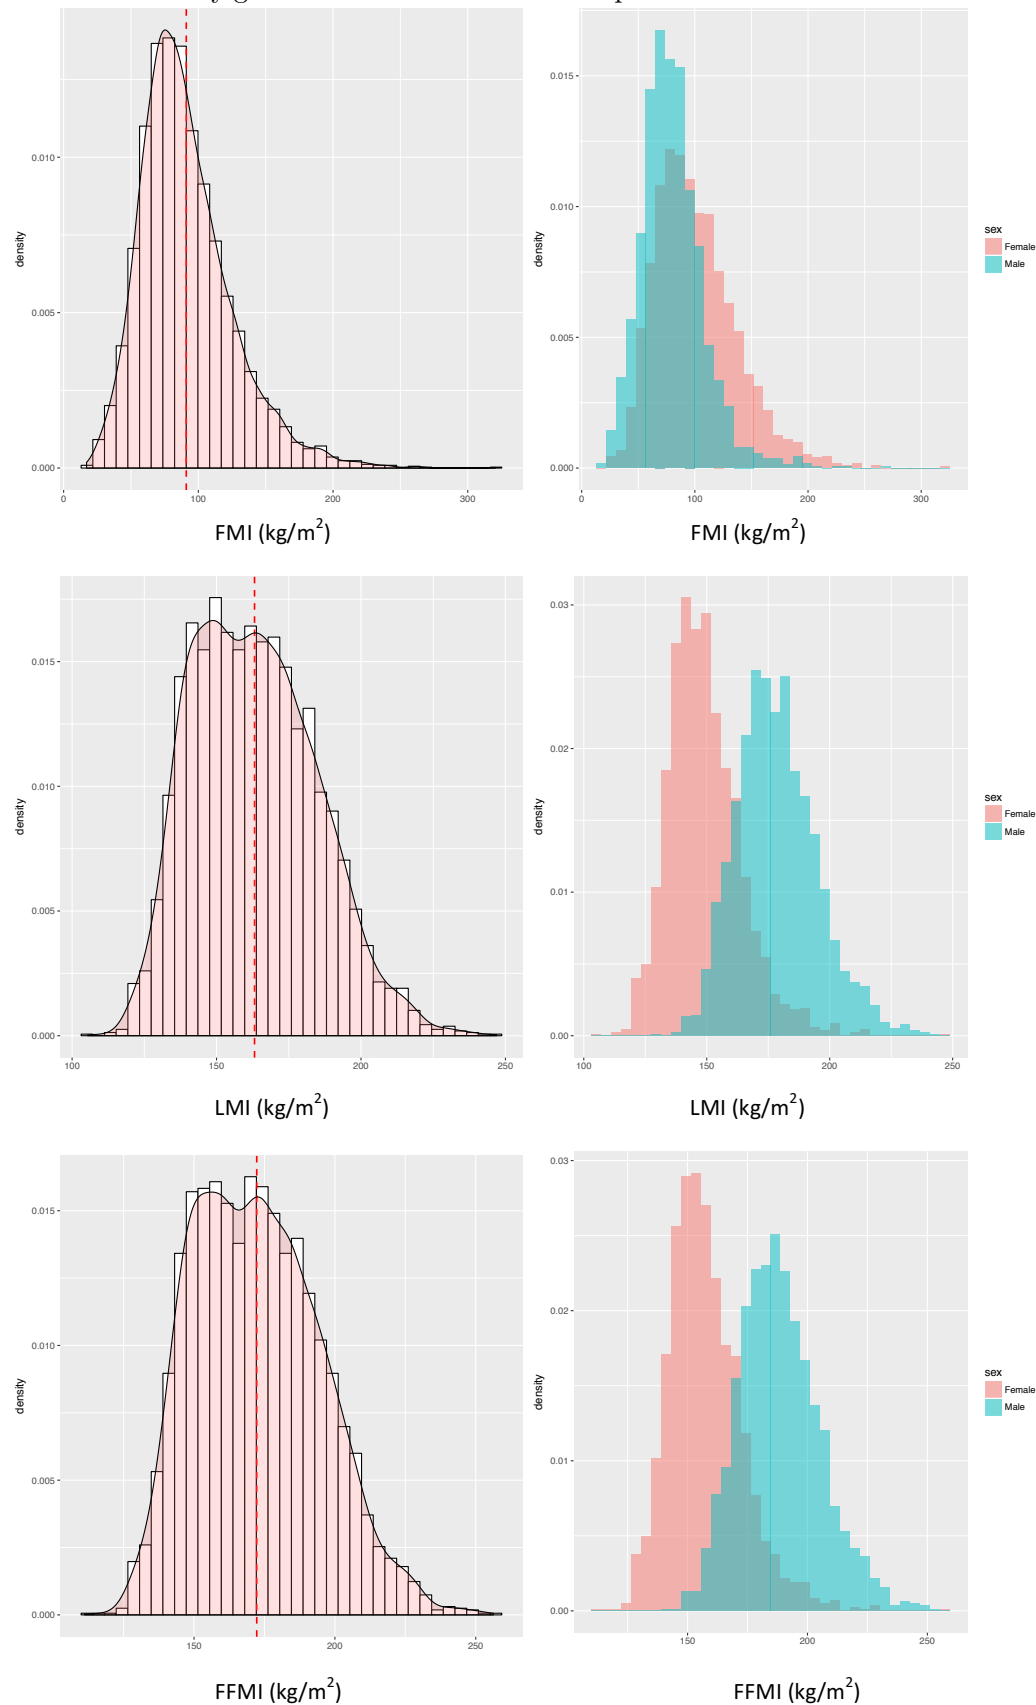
Histograms of the dual-energy X-ray (DXA) measurements fat mass index (FMI), fat-free mass index (FFMI) and lean mass index (LMI) of the 3,901 participants with DXA measurements by gender. The dotted red lines represent the mean values of the measurements.
